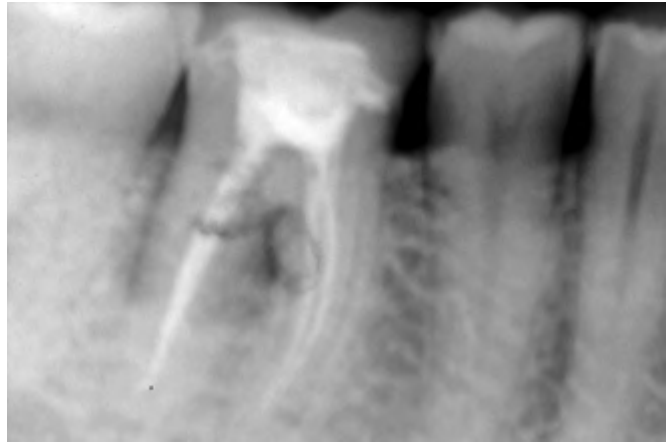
Preoperative radiograph of the mandibular first molar. The external resorption can be visualized in the furcation of the tooth.
